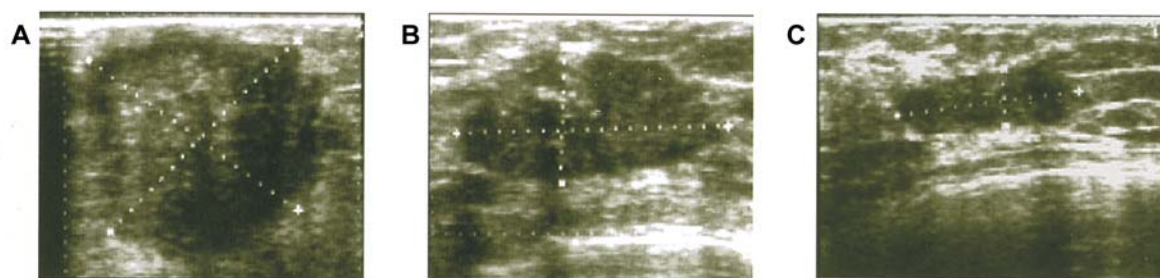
Carcinoma of the breast: B-mode ultrasound. A) Base morphology and volume. B) After two cycles of neoadjuvant chemotherapy: decrease in tumor volume of approximately 50%. C) After four cycles of chemotherapy: decrease in tumor volume > 50%.
